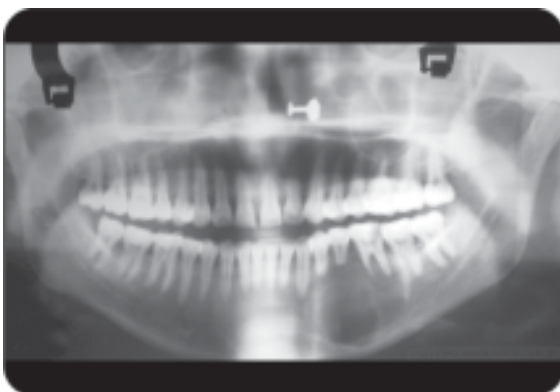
Radiograph of chondrosarcoma
